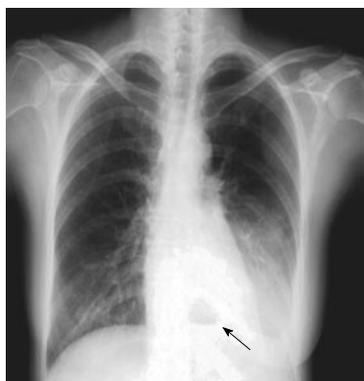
Chest radiograph revealed left side pleural effusion, left lower lobe consolidation and air-fluid level over retrocardiac region air fluid level over the retrosternal area (arrow).
